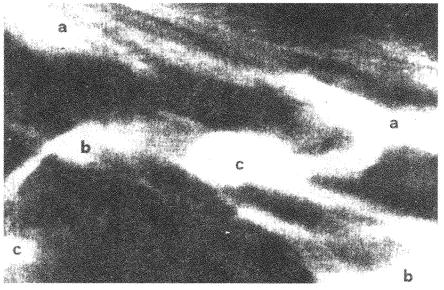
X-ray of the penis root (a) with the prostate (b): two calcifications (c) are well evident.
